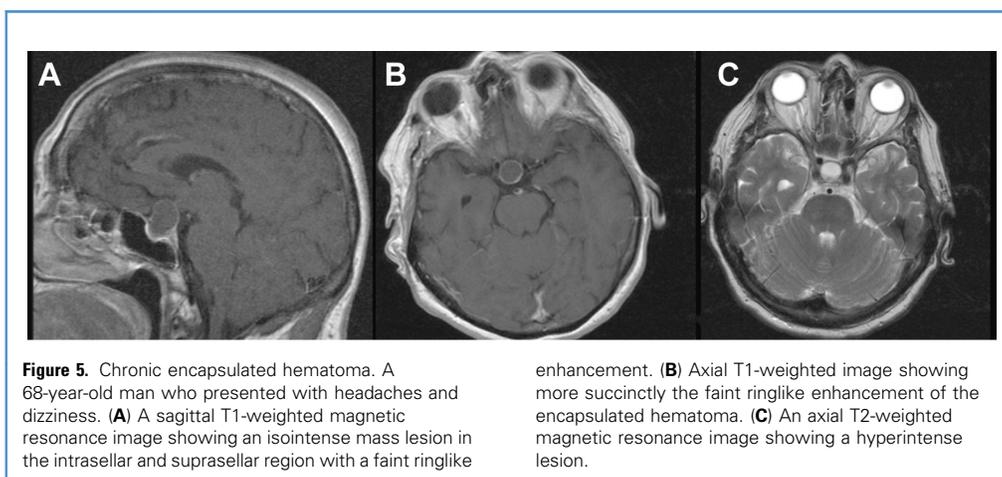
Chronic encapsulated hematoma. A 68-year-old man who presented with headaches and dizziness. (A) A sagittal T1-weighted magnetic resonance image showing an isointense mass lesion in the intrasellar and suprasellar region with a faint ringlike
